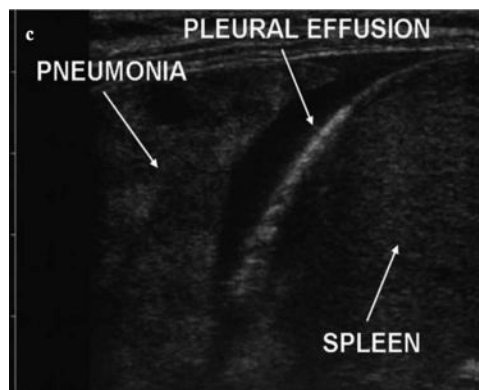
An ultrasound image of the thorax using a linear probe. A hypoechoic collection indicates pleural effusion at the left costophrenic angle. Consolidation is also seen in the lung parenchyma (figure courtesy of Serpil Ozgen).
